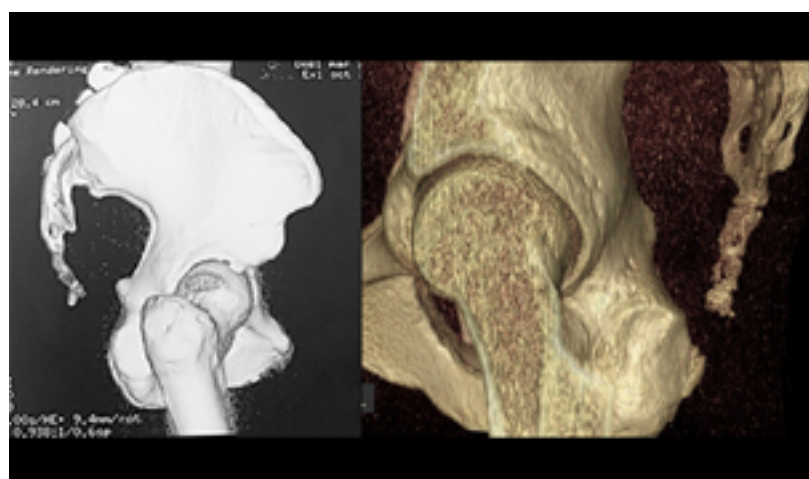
3D CT scan. Large spicule, left. Right, small spicule at the limit of visibility on standard film.
